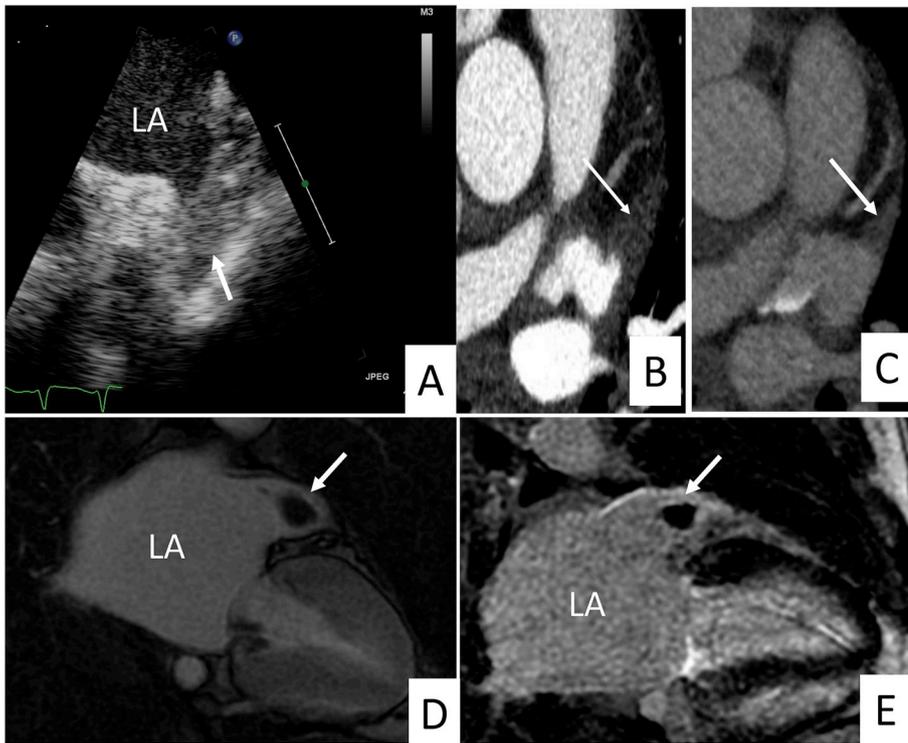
A. TEE showing LAA thrombus (arrow) B, C. Early and delayed post contrast CCT imaging showing LAA thrombus (arrow). D and E. early (C) and late (D) post contrast T1W CMR images showing LAA thrombus (arrow). CCT: cardiac magnetic resonance; CMR: cardiac magnetic resonance; LA: left atrium; LAA: left atrial appendage; TEE: transesophageal echocardiography.
